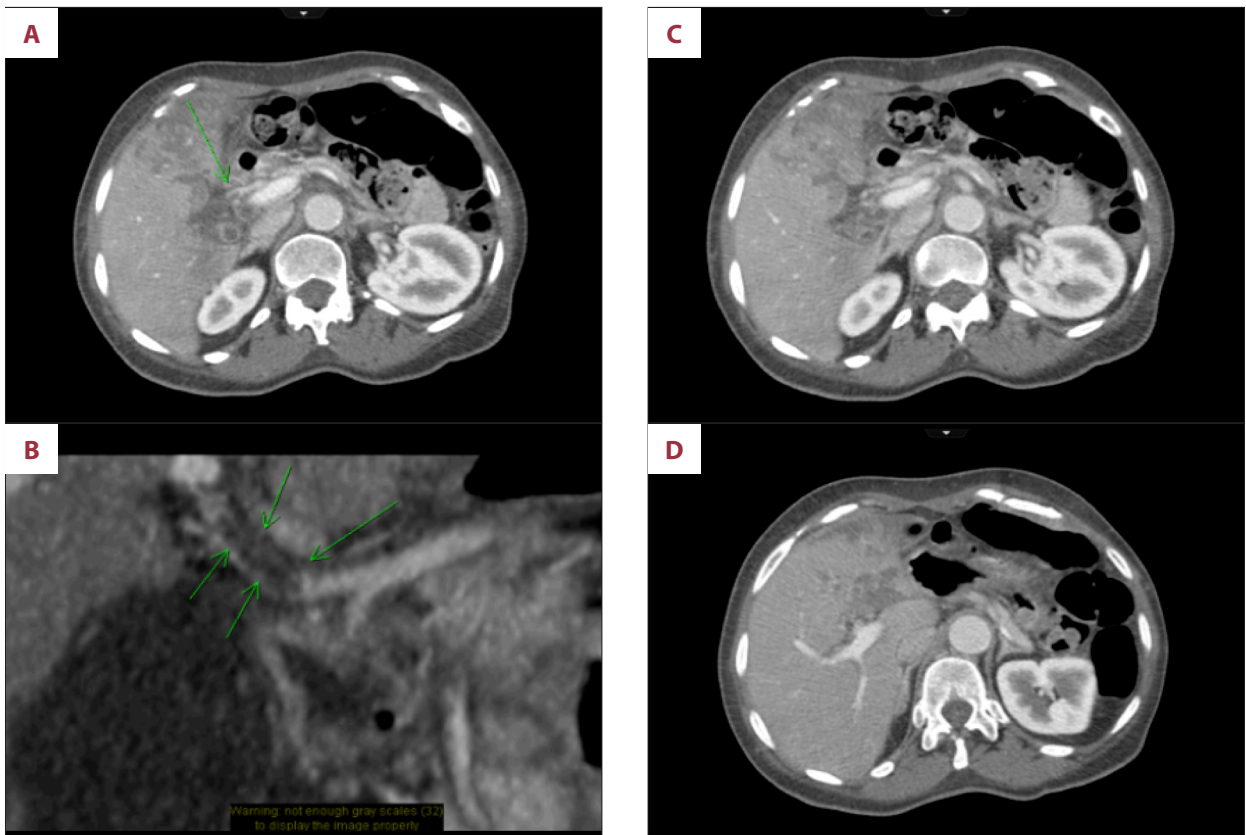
Computed tomography showing hepatic artery thrombosis with multiple peripheral hepatic infarcts. (A) Thrombus noted in proper hepatic artery as pointed by green arrow. (B) Magnified image of clot noted within hepatic artery. (C) Multiple peripheral low-attenuating irregular areas compatible with hepatic infarcts. (D) Evidence of peripheral infarcts in the liver, mostly over left hepatic lobe.
